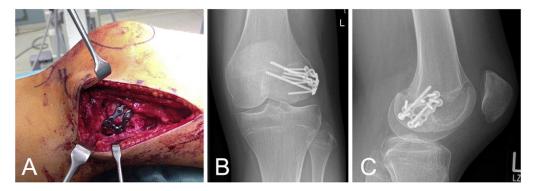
A) intraoperative reduction with lag -screws and locking plate. B) postoperative ap and lateral X-ray.
